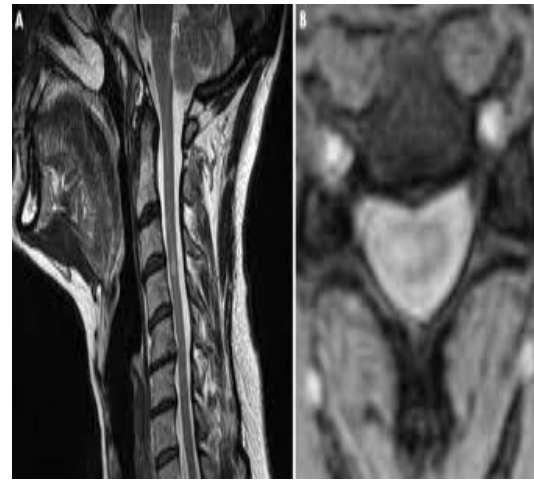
Sagittal and axial T2W MRI: high signal intensity lesion in cervical spinal cord due to MS plaque
